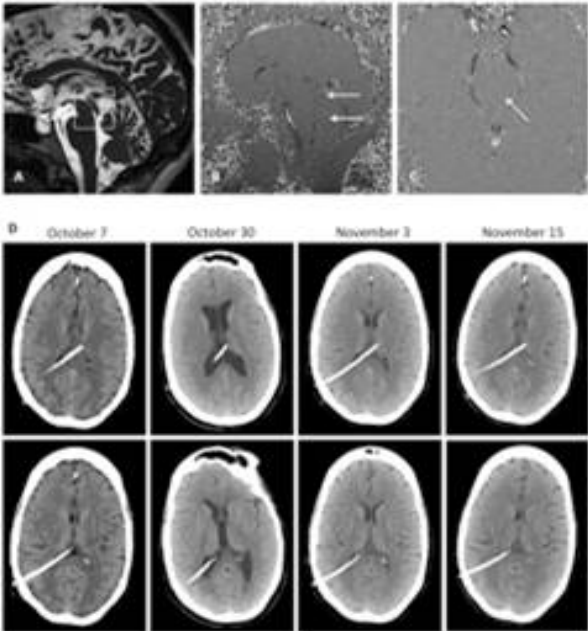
MRI CISS/CINE to support head CT findings of AQS. Sagittal CISS image shows focal obstruction of the cerebral aqueduct (box, A). Sagittal and axial CINE images show absent flow in the cerebral aqueduct (arrows B, C). Serial axial head CT scans showing significant changes in ventricular diameter over the course of 5 weeks (D). The patient received the last adjustment to her shunt valve after the CT scan on October 30. Treatment with dopaminergic therapy was initiated during the time that the last CT scan was completed.
